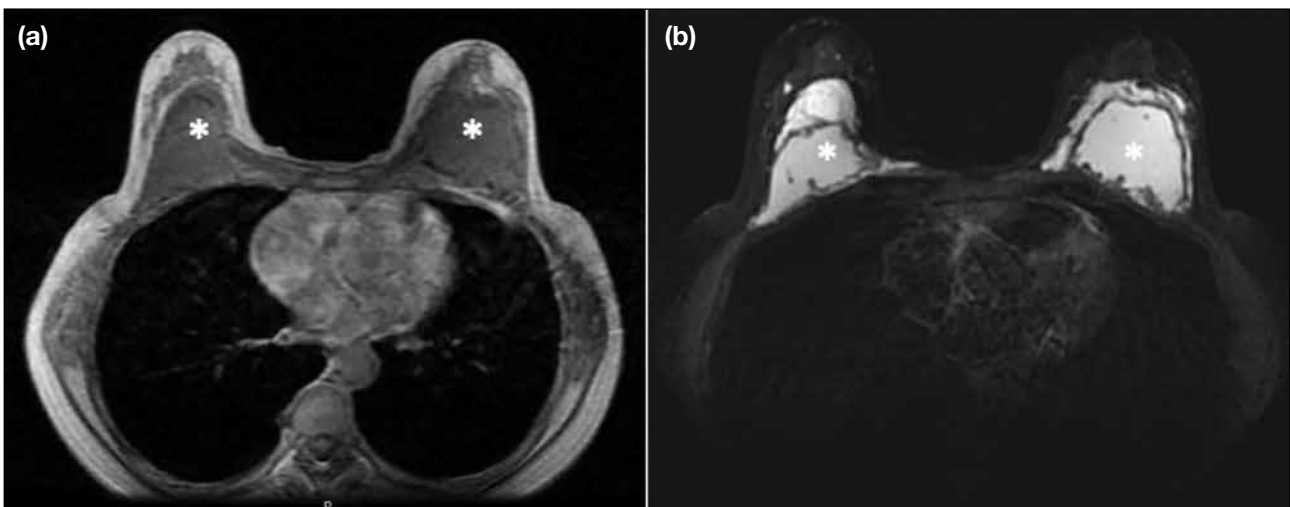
A patient with history of polyacrylamide hydrogel (PAAG) injection. (a) T1-weighted axial magnetic resonance imaging (MRI) and (b) short-tau inversion recovery (STIR) axial MRI showing injected PAAG material as loculated collections (asterisks) in the subglandular breast tissues. Note that the PAAG material demonstrates intermediate T1-weighted signal in breast glandular tissue and hyperintense STIR signal, which could mimic saline bag implant augmentation.
